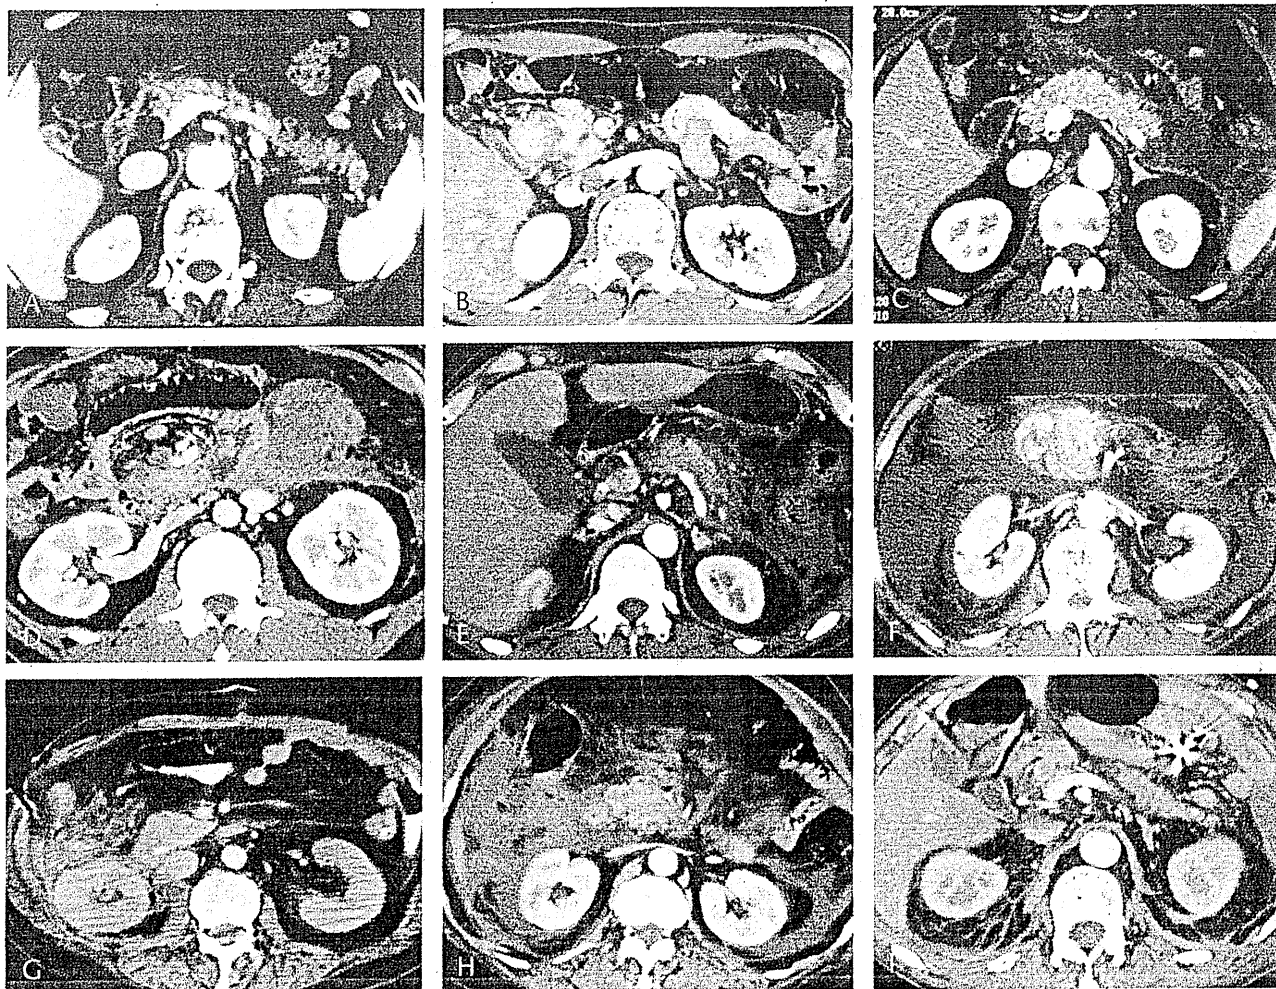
Typical CT images in each RRG. A and B, Grade 1; C–E, grade 2; and F–I, grade 3.
